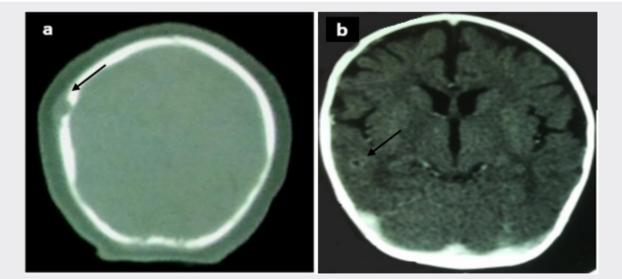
Cerebral computed tomography scan: (a) multiple lacunae in the cranial vault. (b) Intra-axial lesion in the right temporal lobe, measuring 6,5mm hypodense, with peripheral enhancement and no perilesionaledema: Tuberculoma.
